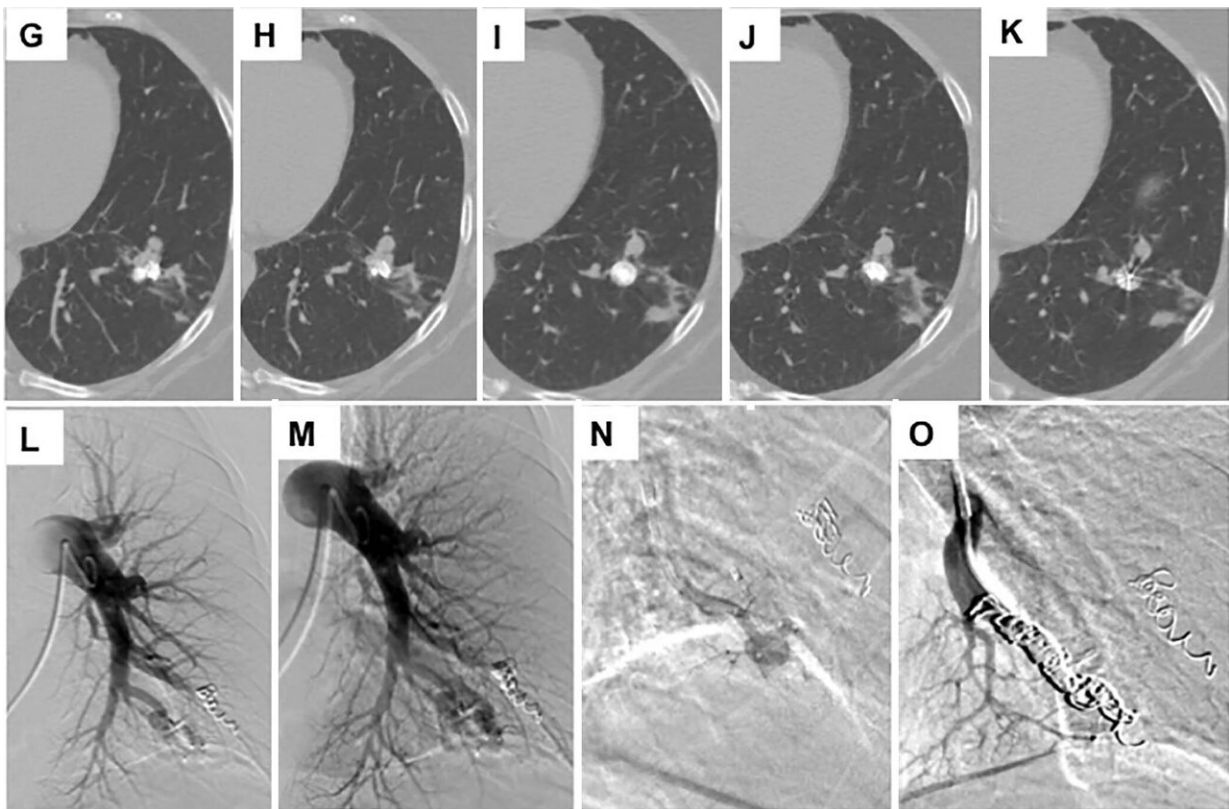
Images in a 68-year-old woman with hereditary hemorrhagic telangiectasia (HHT) and a smoking history of 40 pack-years demonstrating, A, a complex arteriovenous malformation (AVM) at the left base on intravenous contrast-enhanced chest CT scan. B, C, Left pulmonary artery angiogram shows the AVM. D, Image after embolization and after placement of an Amplatzer plug. E, A selective angiogram of the second arterial blood supply to the AVM. F, Angiogram after coil embolization. Credit: Radiological Society of North America
